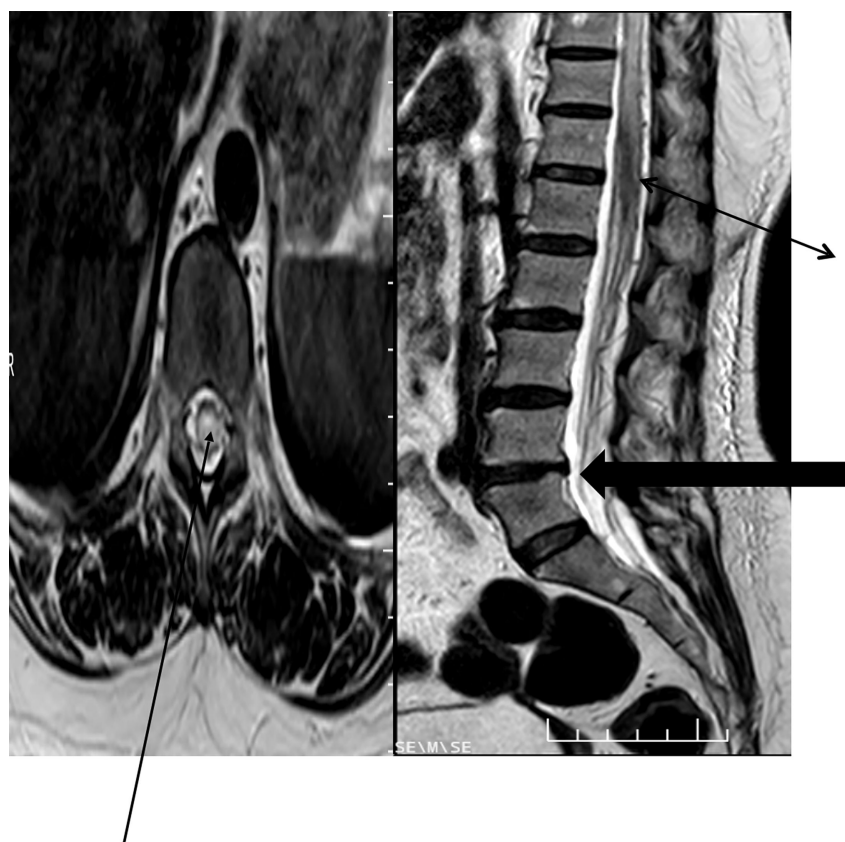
T2 sagittal and axial images of MRI lumbosacral spine showing degenerative changes with L4–L5 prolapsed intervertebral disc (marked with broad black arrow) and hyperintensity in the lumbar cord region (marked with narrow black arrow) with flow voids (marked with double-headed black arrow).
